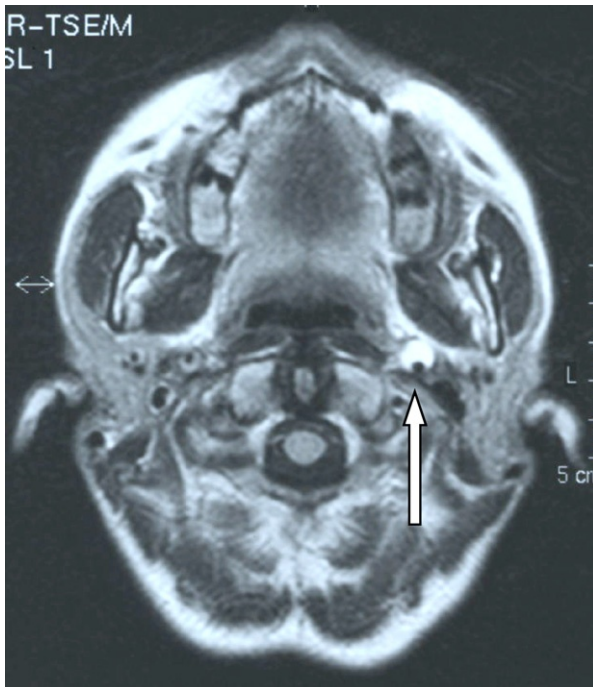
Typical intramural hematoma in a patient with left carotid artery dissection and headache (T₂-weighted axial magnetic resonance imaging scan). The white arrow denotes the carotid artery with an intramural hematoma.
